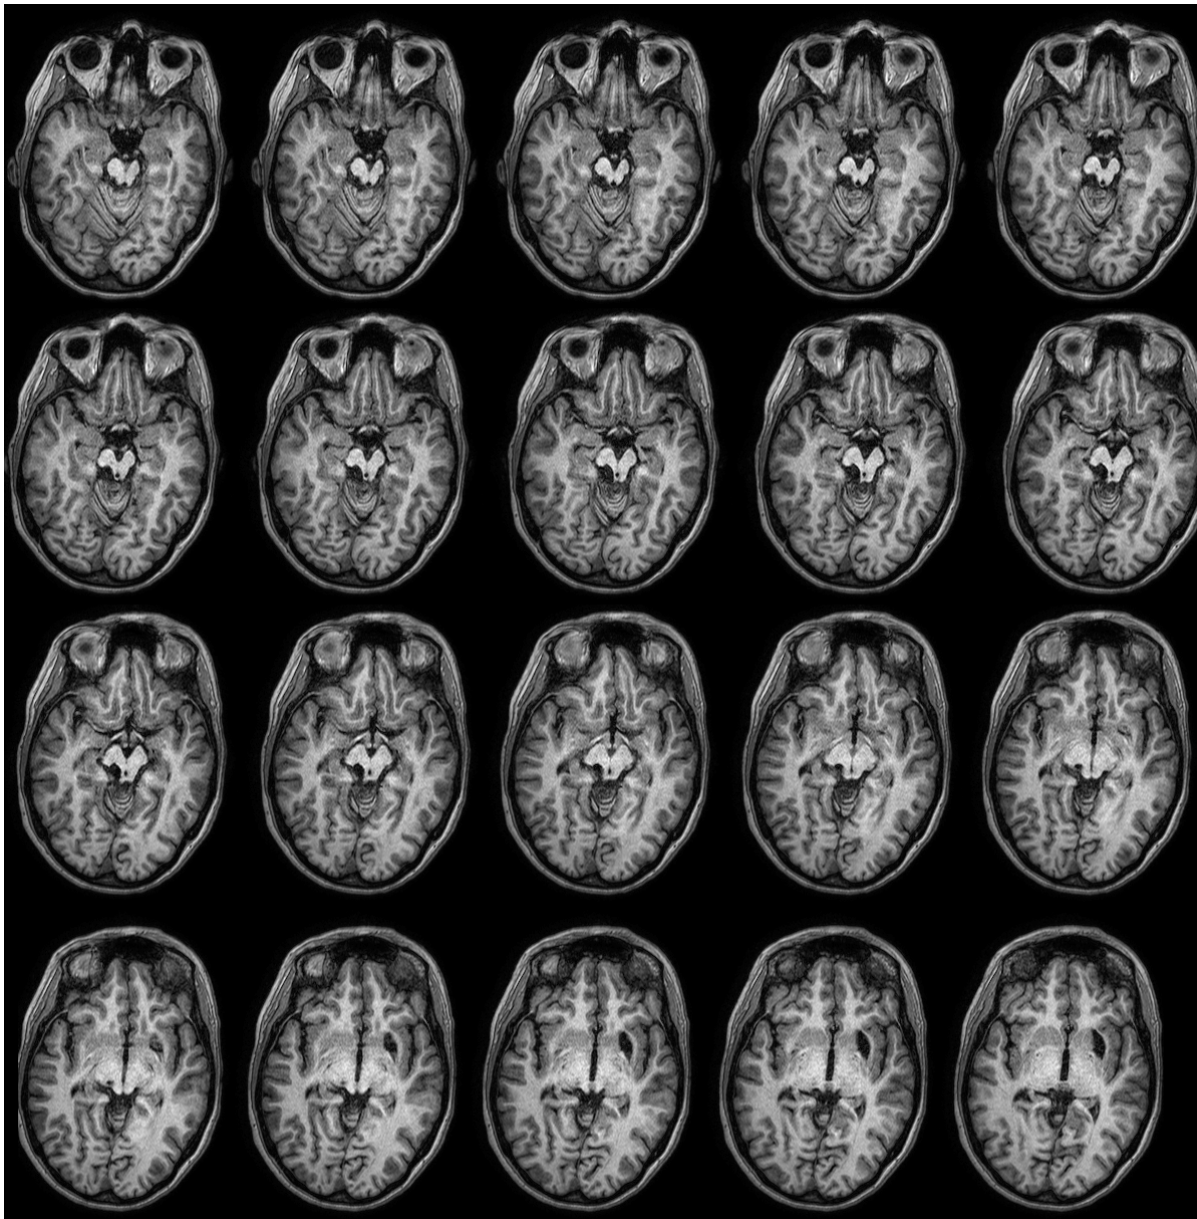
A series of axial MRI T1 sections of LM are shown from lower (upper left) to top (bottom right). The upper two rows display the left IC lesion, and lower row displays the left medial geniculate lesion and the right putamen damage.
